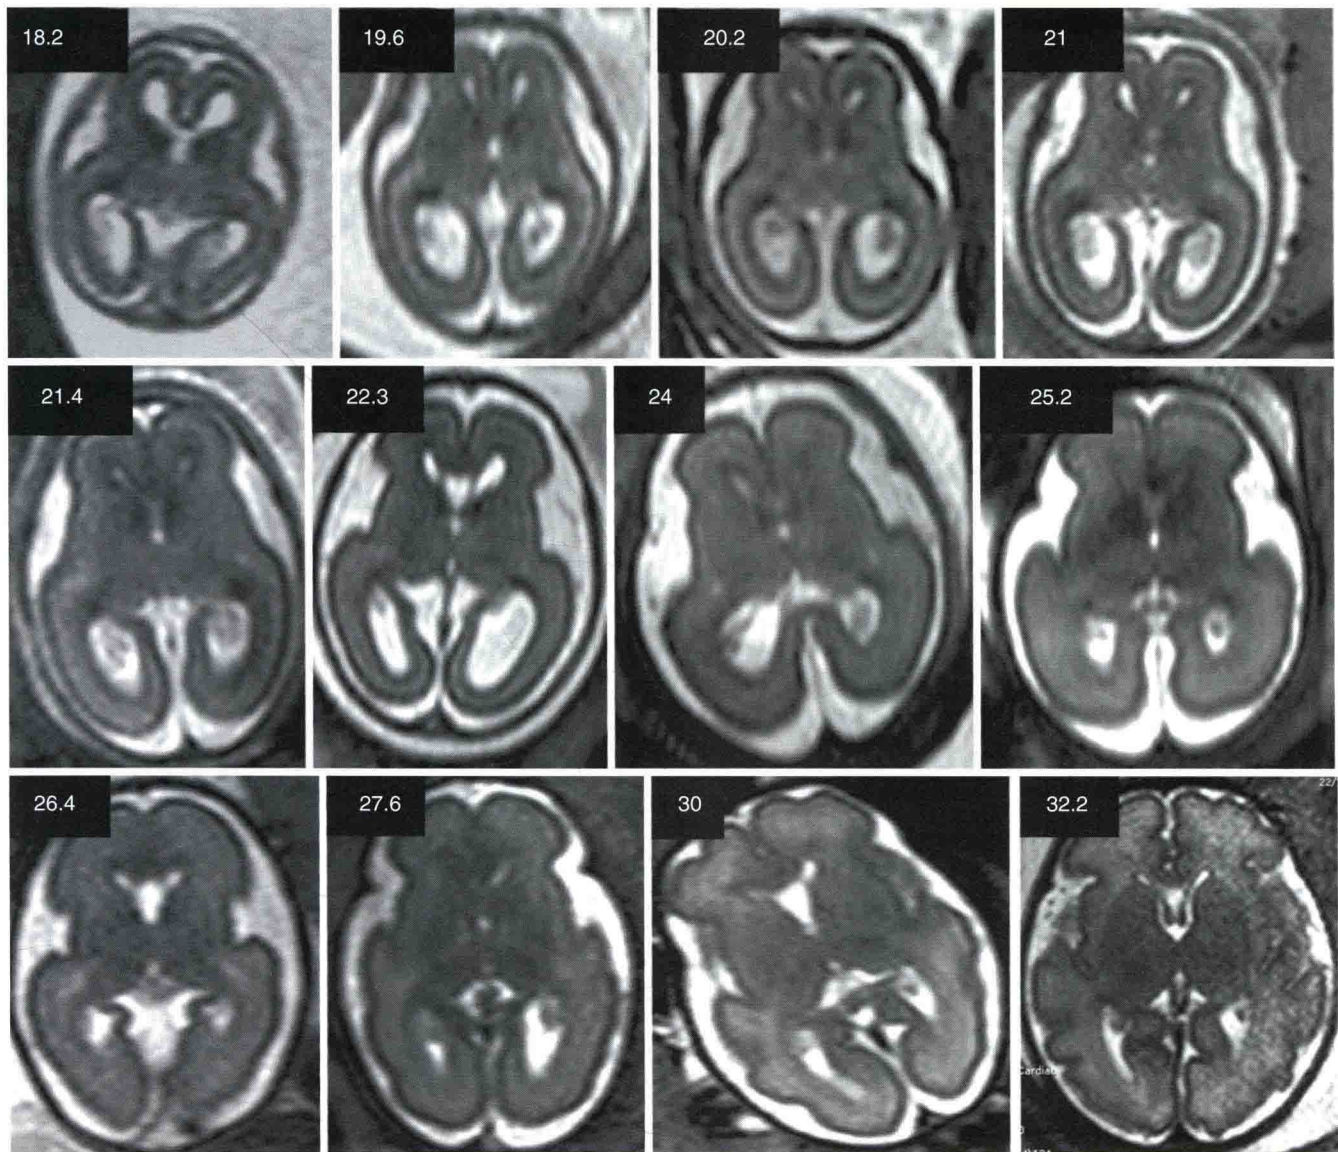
Normal fetal brain development according to fetal MR. Twelve selected cases from 18.2 to 32.2 GW, axial T2-weighted images passing approximately through the thalamus. For the acquisition technique, see the text
